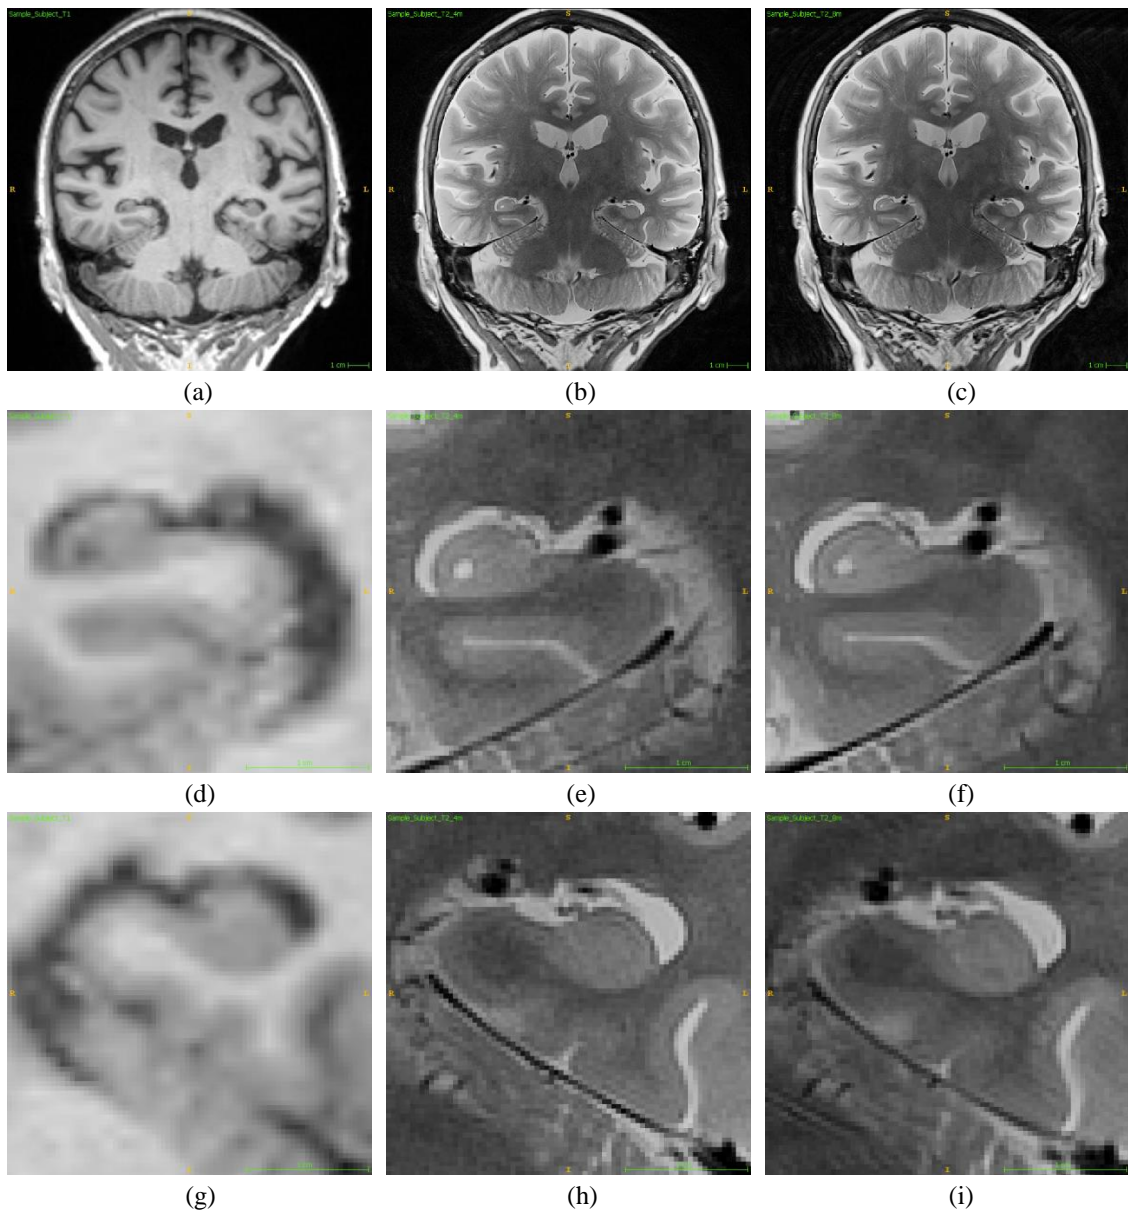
Coronal views: (a-c) Conventional MRI, high resolution MRI, and repeated high resolution MRI. (d-f) Left hippocampal area on conventional MRI, high resolution MRI, and repeated high resolution MRI. (g-i) Right hippocampal area on conventional MRI, high resolution MRI, and repeated high resolution MRI.
